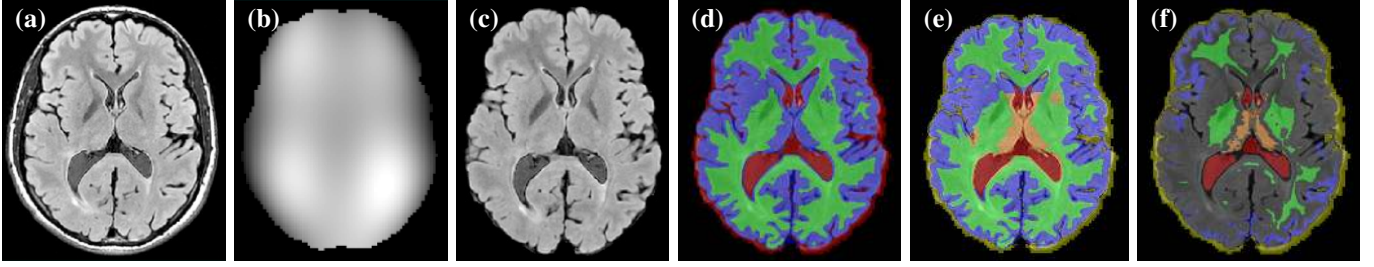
Pre-processing. Based on the original images, such as the FLAIR image (a), a bias field (b) is computed [11] in order to correct (c) the input images. The bias field computation also provides a coarse segmentation into GM, WM and CSF (d). These segments are refined to obtain segments for SGM and V as well (e). Strongly eroding these segments $\hat{S}_\ell^{(0)}$, provides the segments \hat{S}_ℓ that we treat as hard constraints (f) in our framework (cf. Section III-A).
